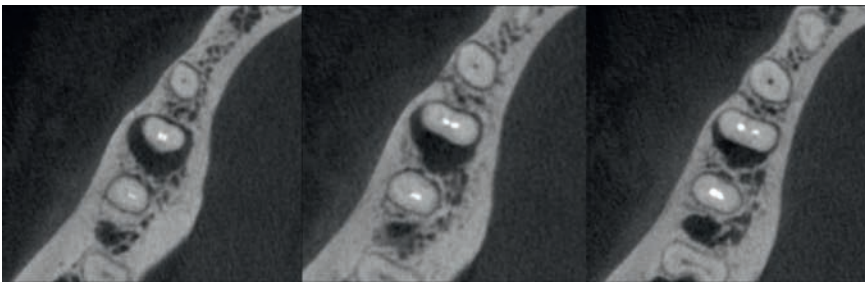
CBCT axial images.
